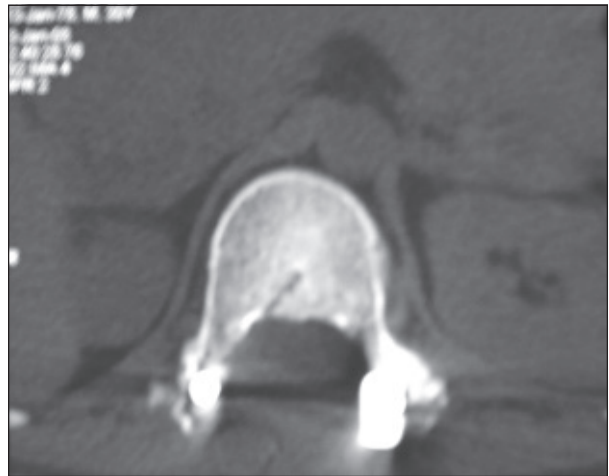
Post Operative CT Scan- Demonstrating clearance of spinal canal
